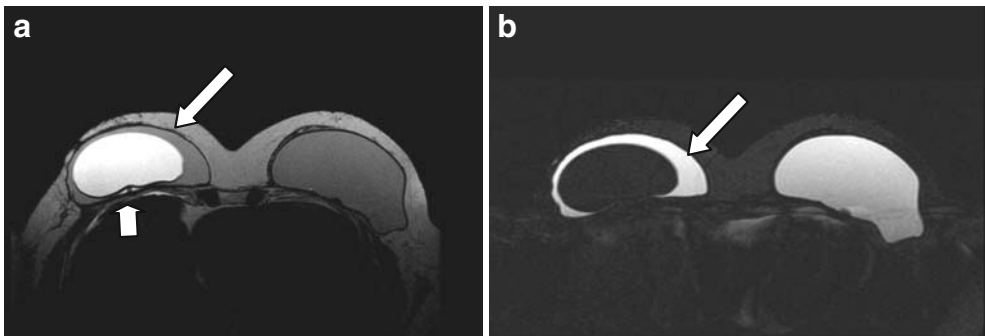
Case number 8020 of October 29th, 2008; 55 year-old patient, right mastectomy in 2003; reconstruction with double lumen expander in 2003; implant in the left breast in 2008; T2-weighted (A) and "silicone only" (B) sequences in the transverse plan showing the double lumen expanders bilaterally (white arrows); note the flexible tube remaining after complete filling in A (small white arrow).
